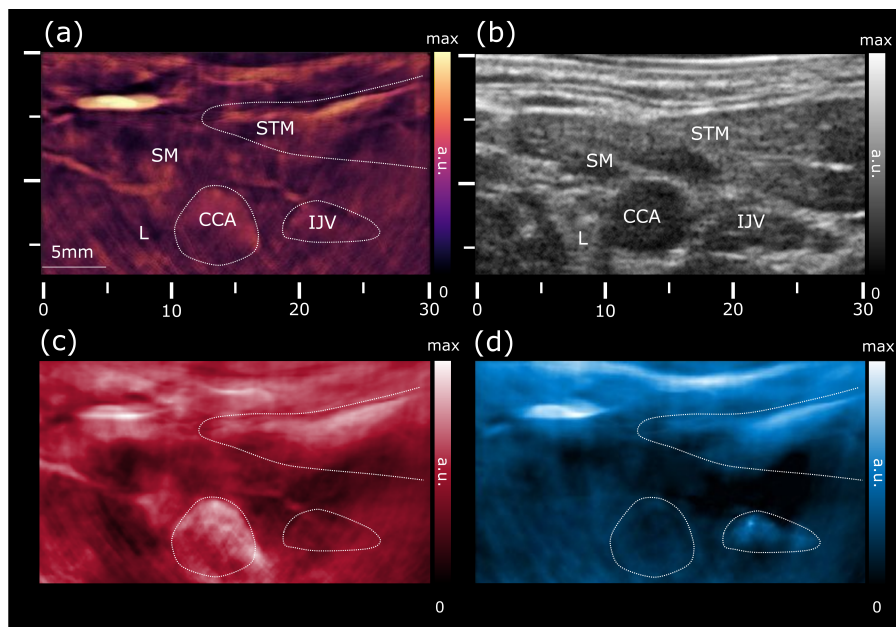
Cross-sectional views of the left common carotid artery in the transverse plane. (a) Optoacoustic image at 800 nm shows increased vascularization of the skin, strap and sternocleidomastoid muscles, allowing for a clear identification of the common carotid artery and internal jugular vein. (b) Ultrasound pulse-echo STA image revealing the common carotid artery and jugular vein as echo-free structures. (c) Map of the unmixed distribution of oxygenated hemoglobin (HbO₂). (d) The corresponding map of deoxygenated hemoglobin (Hb). CCA: common carotid artery; STM: sternocleidomastoid muscle; SM: strap muscle; IJV: internal jugular vein; L: thyroid lobe.
